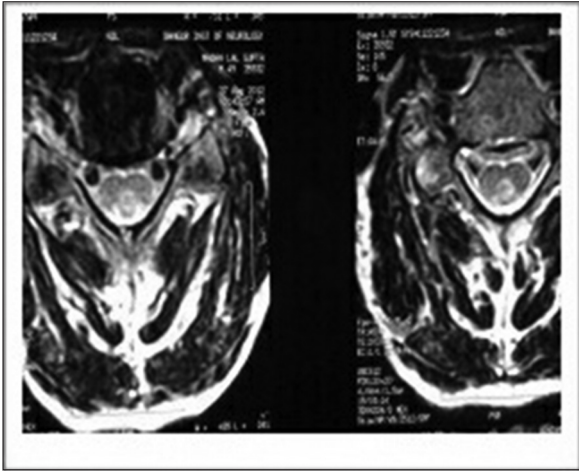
Magnetic resonance imaging spine showing signal changes in posterior column cervical cord Vitamin B12 deficiency
